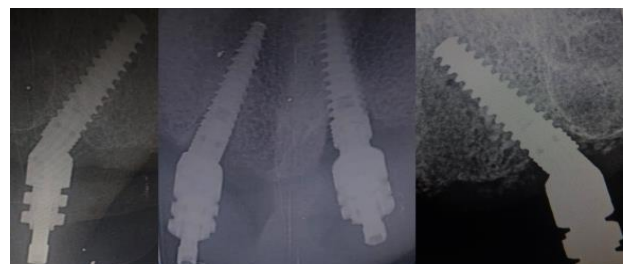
JIG TRIAL VERIFIED RADIOGRAPHICALLY
